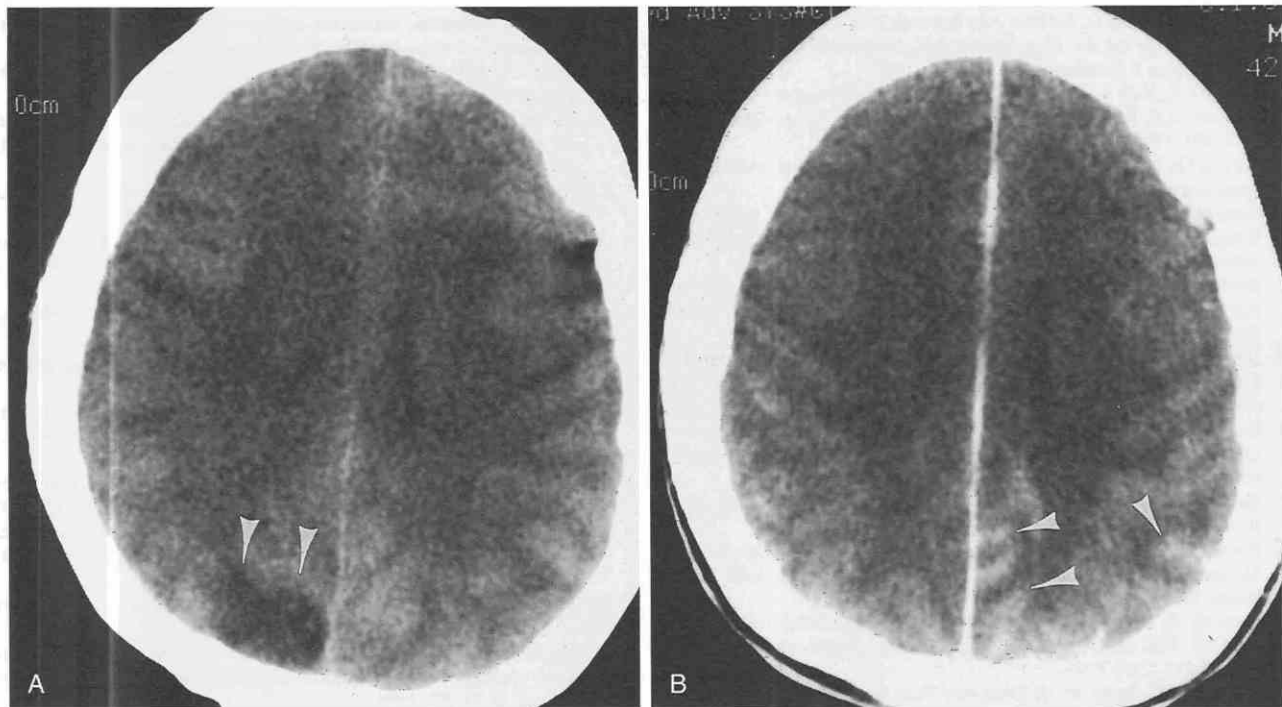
Carcinomatous encephalitis. *A*, Axial CT of the head obtained before contrast medium shows hypoattenuation in the posterior parietal lobe (*arrowheads*) in a 42-year-old patient who presented with a 4-month history of seizures. *B*, After contrast administration, pial enhancement is minimal (*arrowheads*). The patient was initially thought to have subarachnoid hemorrhage, but autopsy showed extensive adenocarcinoma in the perivascular spaces and meninges, with multiple ischemic foci in the brain and a primary focus in the lung.
